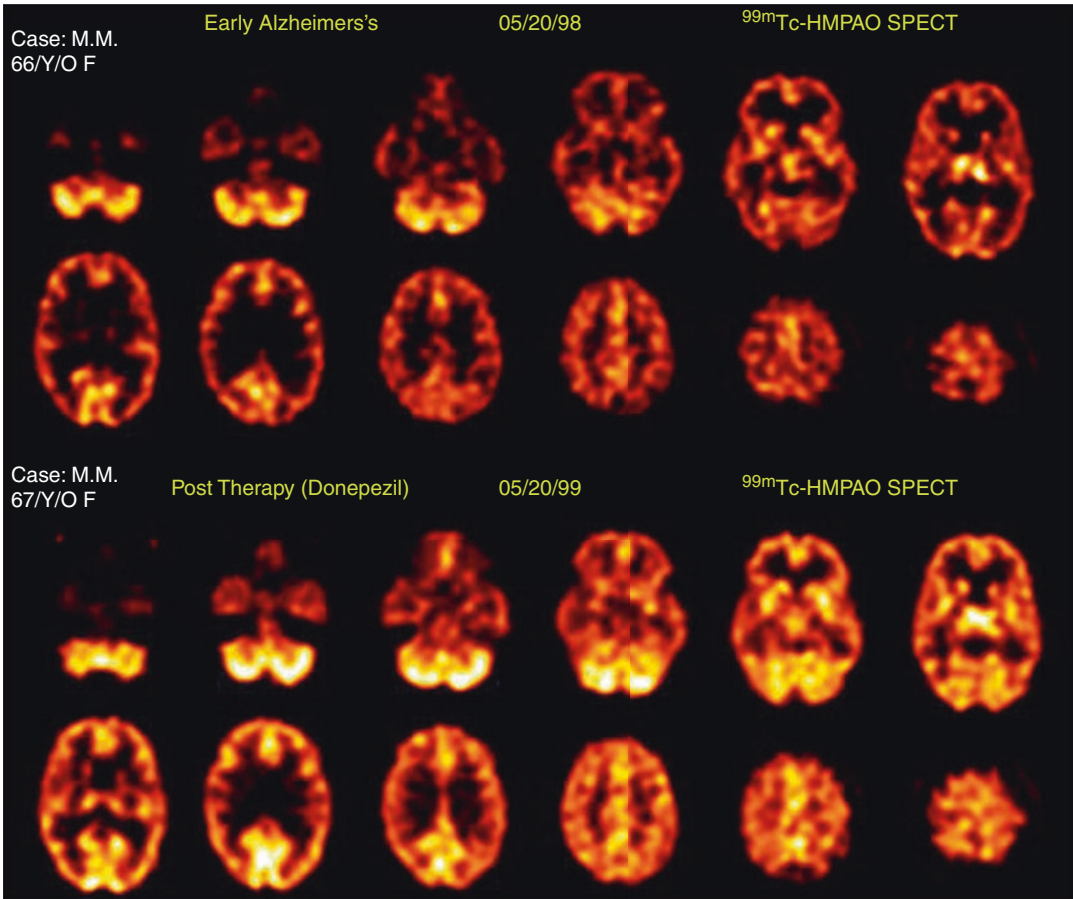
^{99m}Tc -HMPAO brain SPECT scan of a 66-year-old patient with early Alzheimer's disease who was treated with donepezil. The top two rows of images show sequential transverse sections from this patient's ^{99m}Tc -HMPAO scan before beginning therapy. There is
